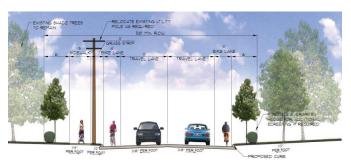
Image credit: Western Connecticut Council of Governments, Transportation Plan for Lower Route 202, Brookfield, CT -Appendix A - Route 202 Complete Streets Evaluation
